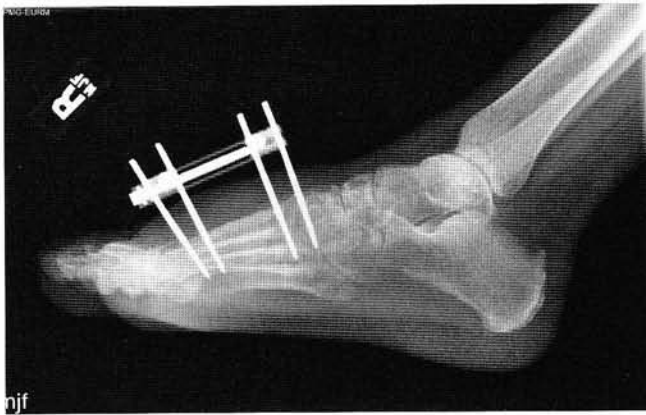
Postoperative lateral radiograph at 2 months following distraction process
